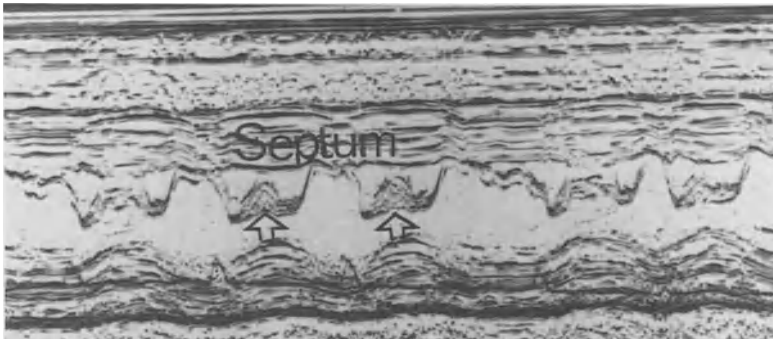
M-Mode echocardiogram in hypertrophic cardiomyopathy showing disproportionate septal hypertrophy and SAM (arrows).
